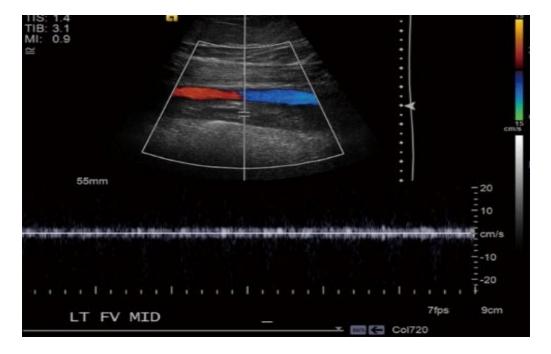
Venous color- flow Doppler. US Doppler imaging of the left femoral vein showing complete occlusion by a heterogeneous thrombus with dilation of the vein at the site of thrombosis (Stone *et al.*, 2017).
